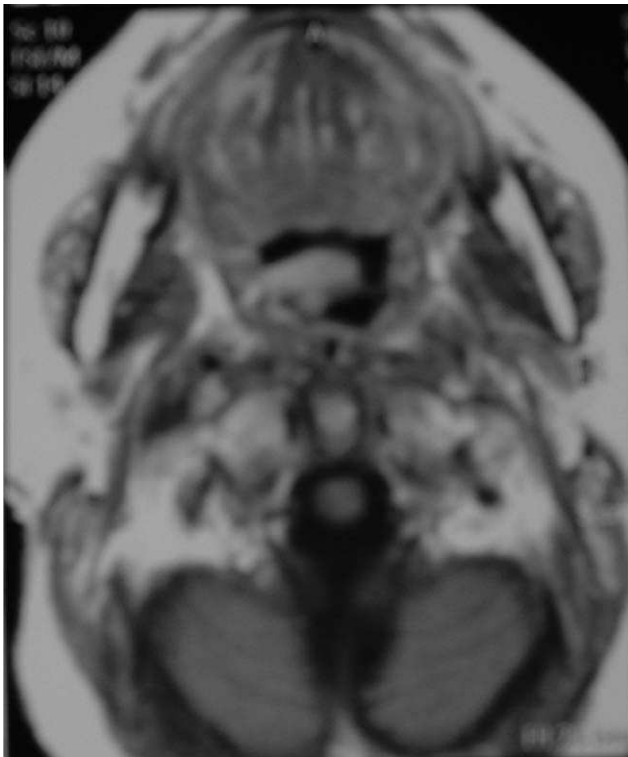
The MRI shows a hypervascularised and hypertrophied uvula.
